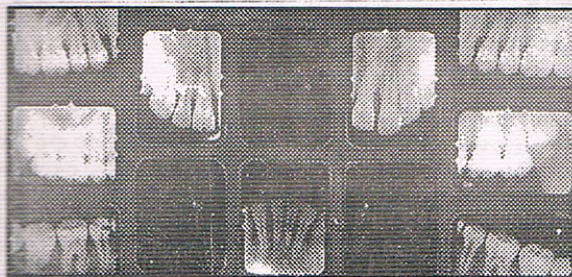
Preoperative IOPA X-Rayx
